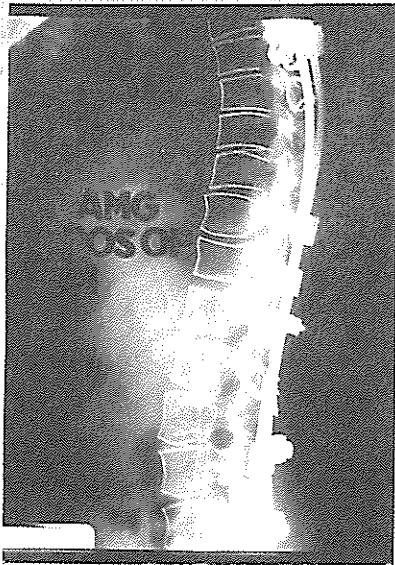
Follow up lateral X-ray, notice physiological curves included.
